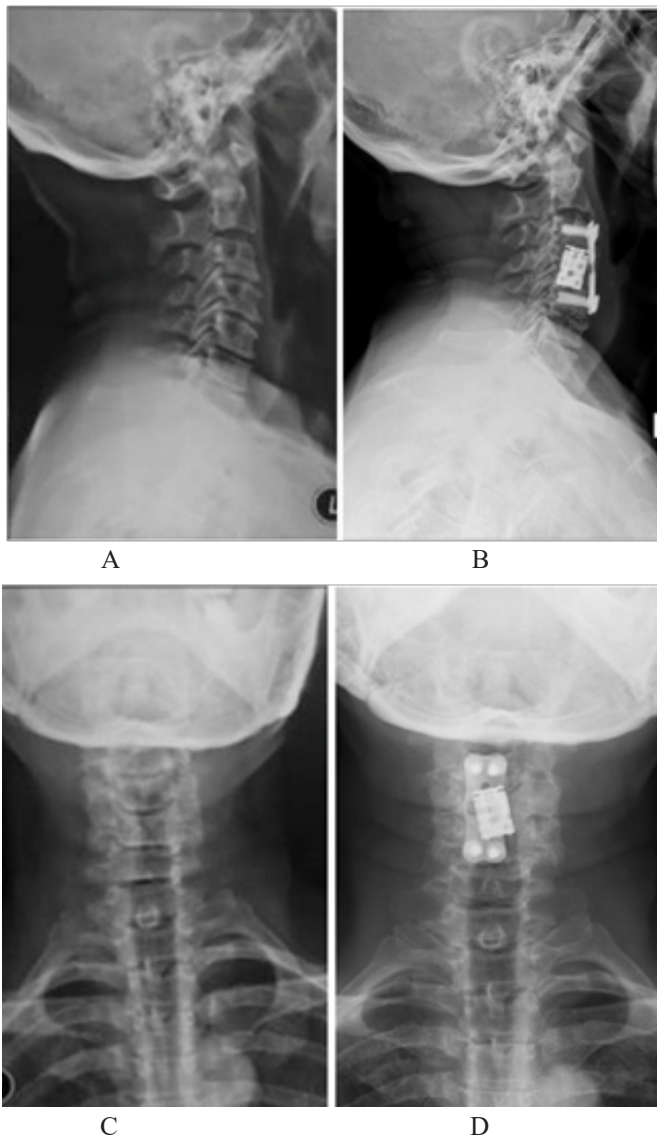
Preoperative and postoperative cervical X-ray images.
